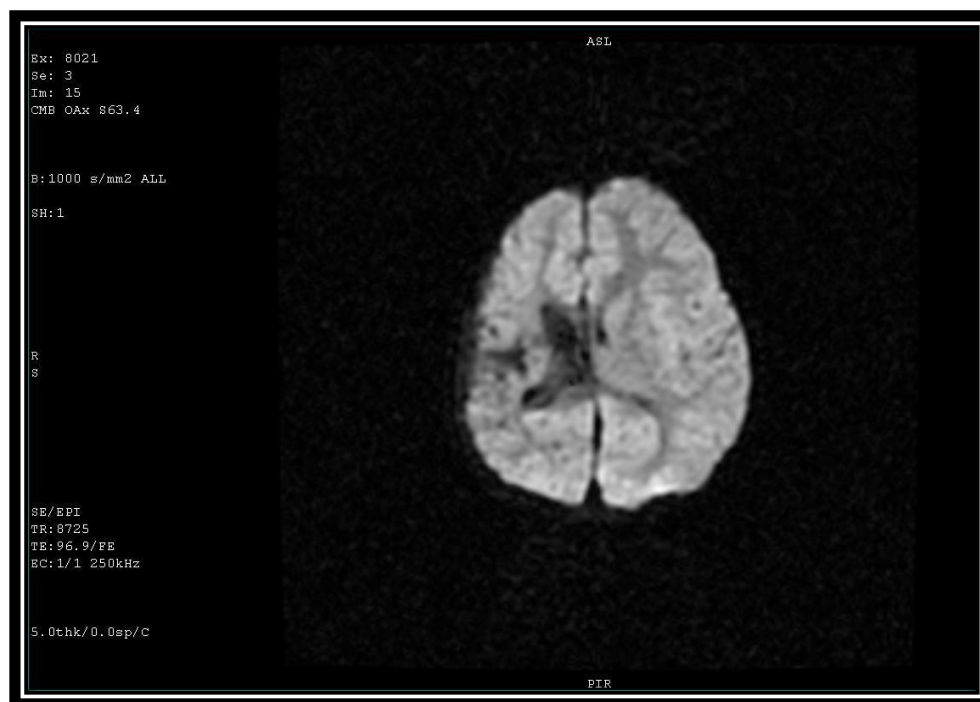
T2-weighted M.R.I. Axial Image showing diffuse right cerebral atrophy with ex-vacuo dilatation of right lateral ventricle
